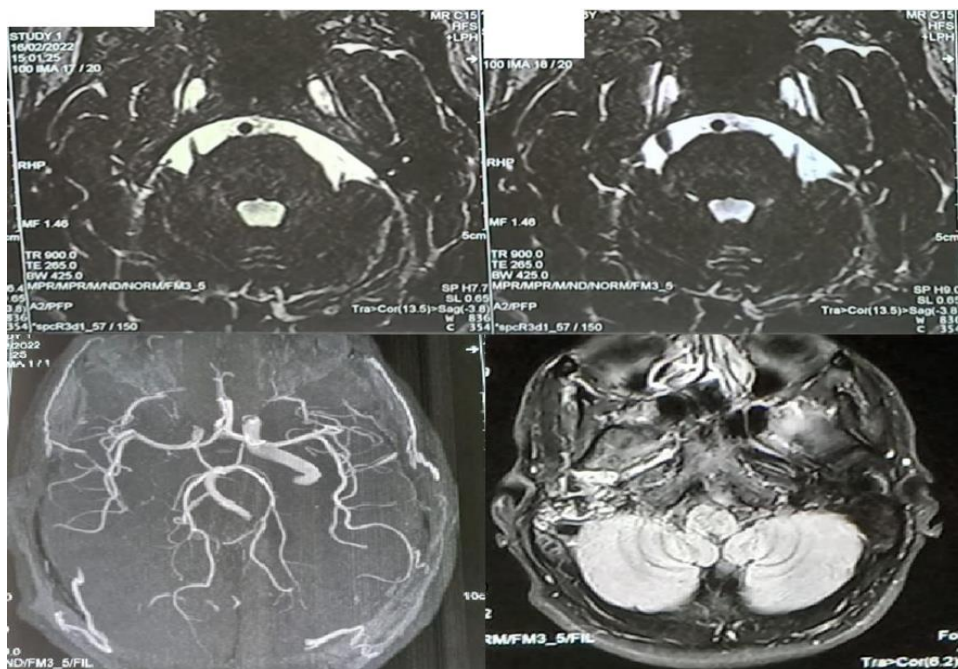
different MRI sequences revealing showing a lack of opacification of the right intrapetrous and cavernous segments of the right internal carotid artery
